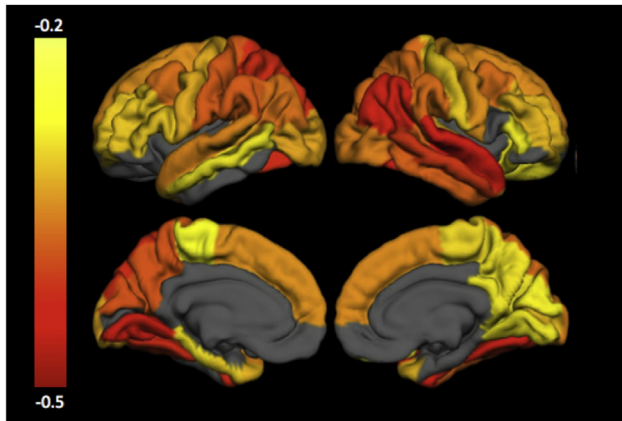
Relationship between antecedent cortical atrophy and current PET Tau, controlling for baseline age, gender, and current florbetapir mean cortical SUVR in cognitively normal and AD participants.
